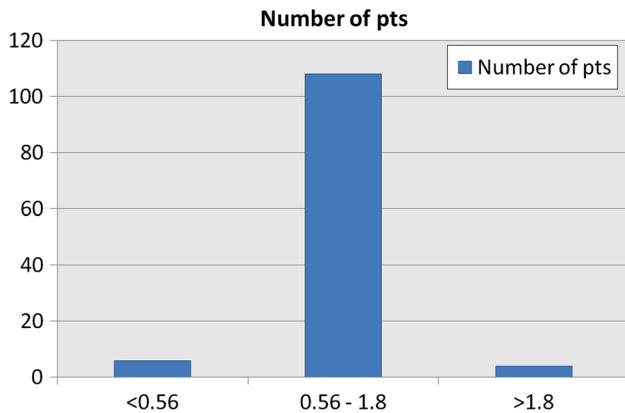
Pelvic radiograph rotation as measured by the obturator index for all patients
